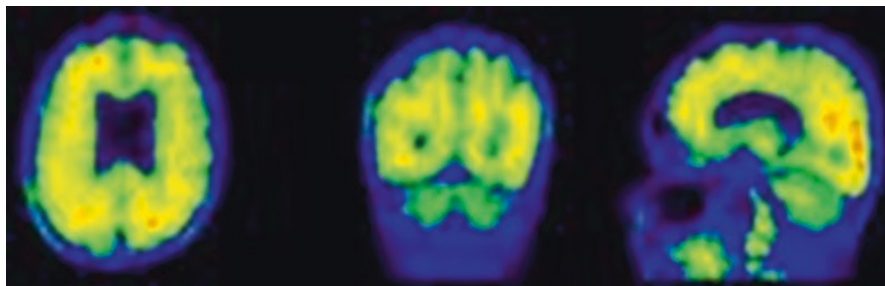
Axial, coronal, and sagittal PET images showing ^{18}F AV45 standardized uptake value ratio (SUVR) image of an HIV+ individual showing high AV45 uptake in the *Precuneus* and the occipital region
